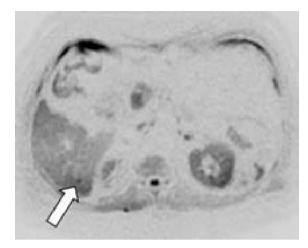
Small metastasis (*arrow*) of pancreatic adenocarcinoma visible only in DWI MRI in hepatic segment VI
